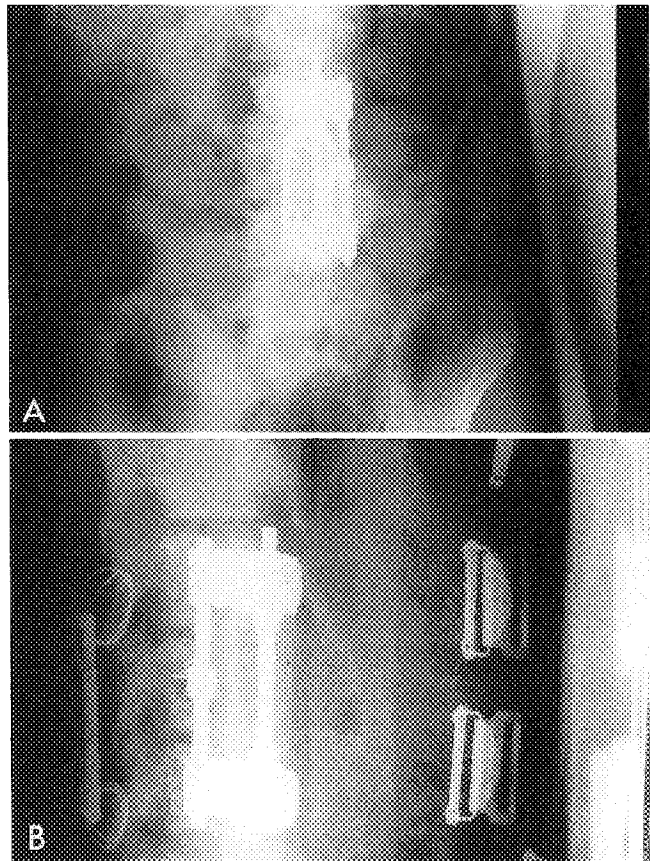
A, B. Anteroposterior and lateral radiographs after excision of the lesion following a two-staged procedure. Note the Dunn instrumentation anteriorly and Luque rectangle posteriorly.
